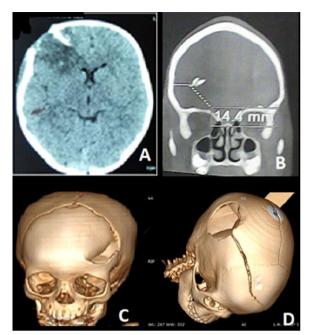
A Axial section brain CT showing a right frontal depressed fracture, B Coronal reconstruction CT showing an intracranial bone fragment, C 3D reconstruction CT showing a left frontal depressed fracture, D 3D reconstruction CT showing a right parieto-occipital depressed fracture + a right fronto-parietal linear fracture
